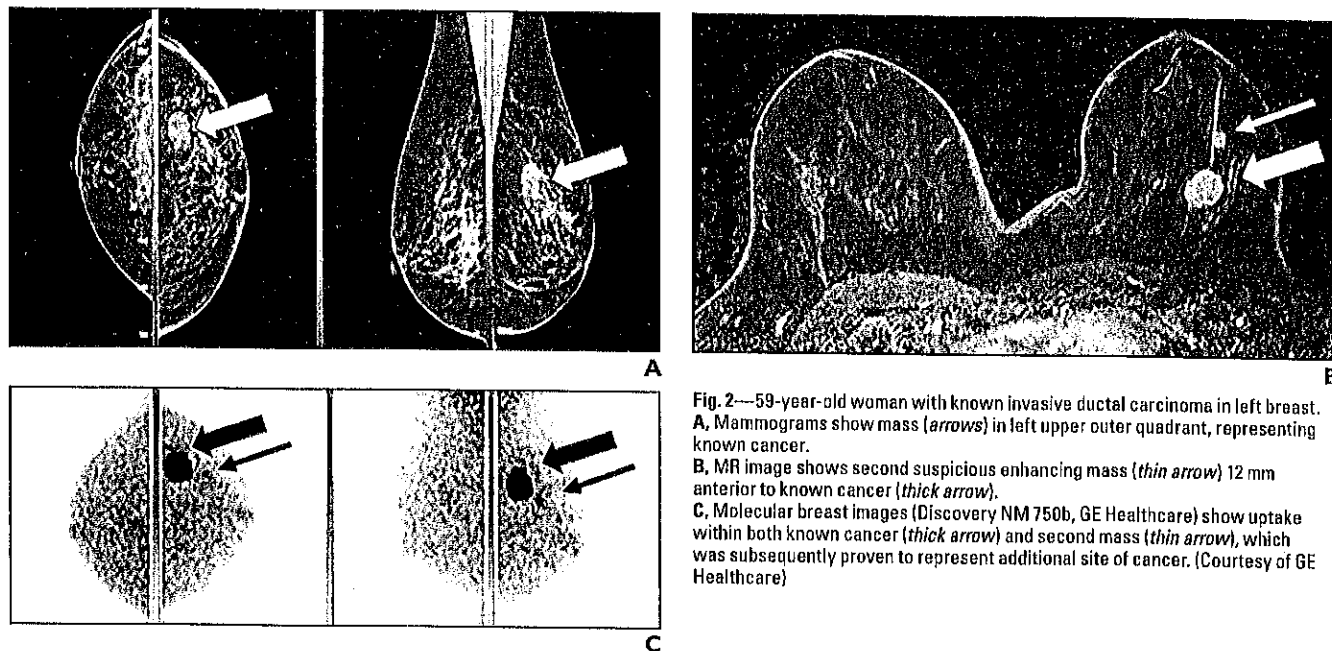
59-year-old woman with known invasive ductal carcinoma in left breast. A, Mammograms show mass (arrows) in left upper outer quadrant, representing known cancer. B, MR image shows second suspicious enhancing mass (thin arrow) 12 mm anterior to known cancer (thick arrow). C, Molecular breast images (Discovery NM 750b, GE Healthcare) show uptake within both known cancer (thick arrow) and second mass (thin arrow), which was subsequently proven to represent additional site of cancer. (Courtesy of GE Healthcare)
